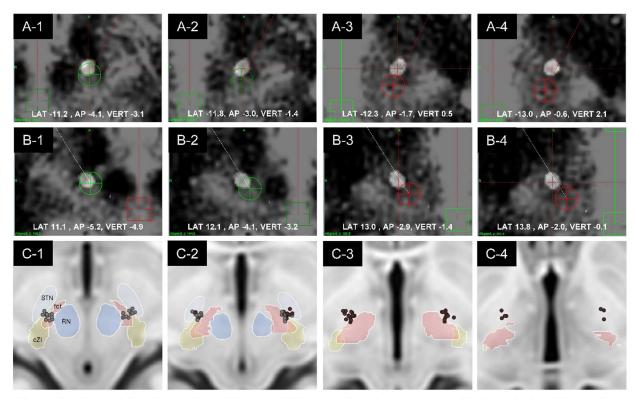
Contact locations. Both PSA and STN were directly targeted on high-resolution T2-weighted images. The trajectory was planned by using the PSA as the primary target. The coronal and sagittal angles were adjusted to obtain a trajectory traversing the STN target and to avoid sulci, blood vessels, and ventricles. The location of the ventro-most to dorso-most contacts of left [(A-1)-(A-4)] and right [(B-1)-(B-4)] lead were shown. (C-1)-(C-4) showed the active contact location of the PSA stimulation (grey circle) and STN stimulation (brown circle) condition. The AC-PC based coordinates with respect to the midcommissural point for PSA stimulation condition were as follows: lateral 11.0 (SD 2.3) mm, vertical -4.3 (SD 1.4) mm, axial -3.3 (SD 1.6) mm. The AC-PC based coordinates for STN stimulation condition were as follows: lateral 12.5 (SD 1.5) mm, vertical -2.5 (SD 1.4) mm, axial -0.9 (SD 1.5) mm.
